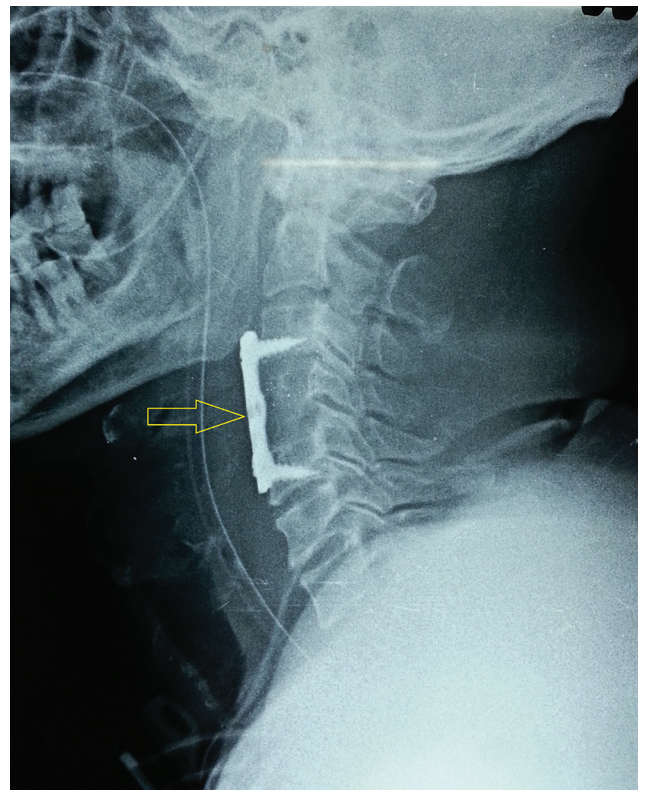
Lateral X-ray cervical spine (postoperative). Yellow arrow shows screw, plate, and bone graft in situ. Screws in C3 and C5 vertebral body.
